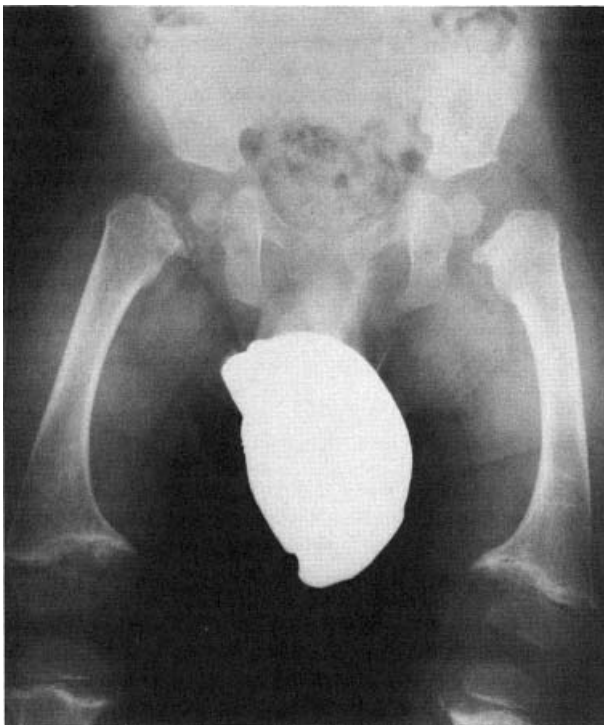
Radiograph of the pelvis and lower extremities of a 5-year-old child with metaphyseal chondrodysplasia, Schmid type. The tubular bones are moderately short and the metaphyses are flared, cupped, and irregularly mineralized.
